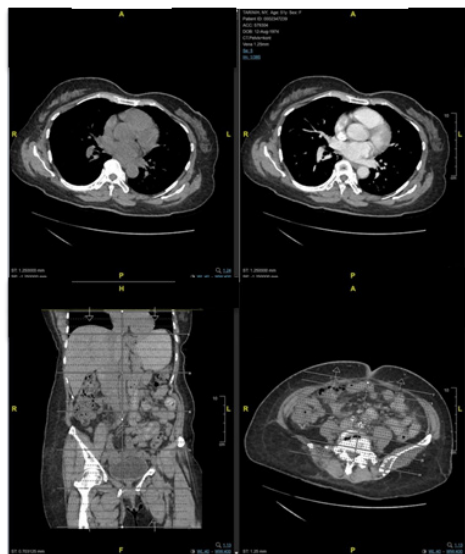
Contrast-Enhanced CT Scan of The Patient Demonstrating Extension of Endometrial Carcinoma and Suggesting Parametrial Involvement
